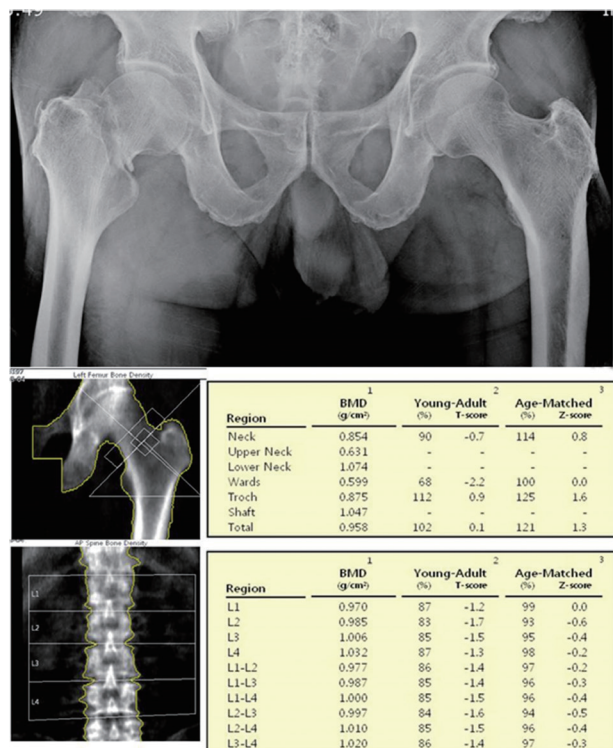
A fracture of the right femoral neck in a 76-year-old male patient is shown on a preoperative radiograph. The fracture was caused by a simple fall from a bed. There was no finding of osteoporosis on dual energy X-ray absorptiometry measured at the proximal femur and lumbar spine.
